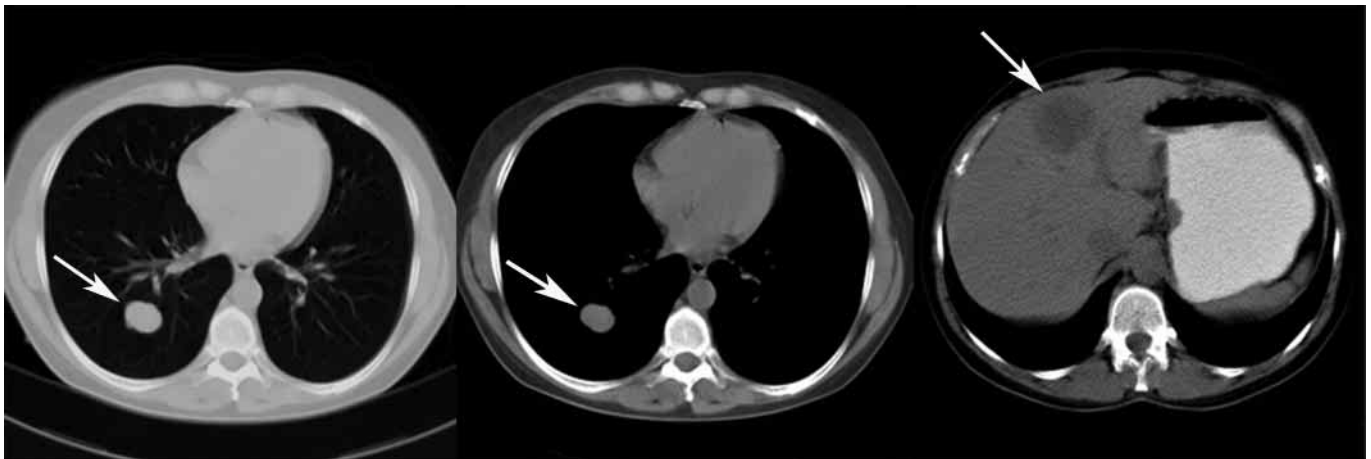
Patient's CT findings before therapy 2001. Lung metastases are clearly evident in both lung and mediastinal window (arrows) as well as
